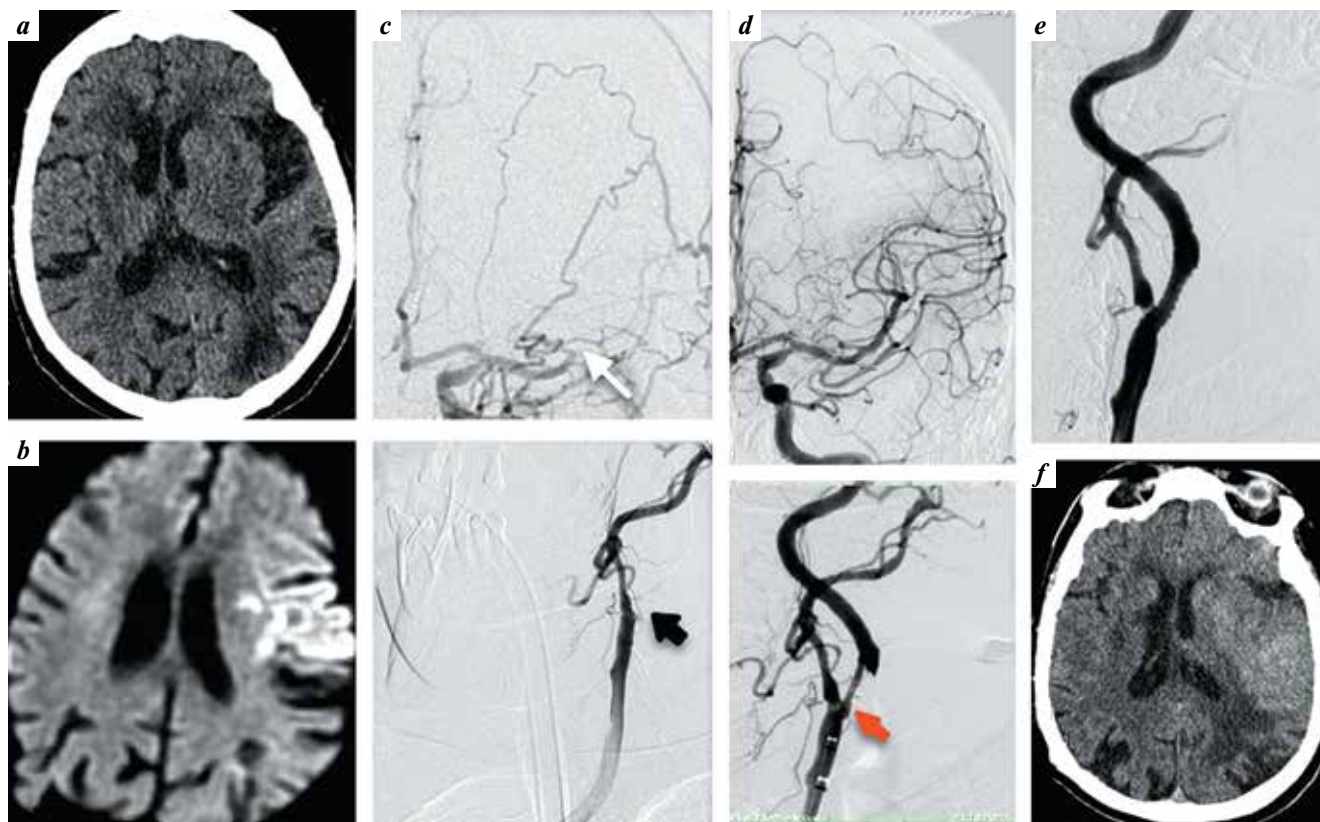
Data from computed tomography (CT), magnetic resonance imaging (MRI) and cerebral digital subtraction angiography of an 83-year-old patient hospitalized with an acute ischemic stroke symptoms in 320 minutes after the onset of the disease: a – CT scan at admission; b – MRI (DWI mode) at admission: hyperdense zone in the left temporal lobe; c – left carotid cerebral angiography at admission: occlusion of the extracranial internal carotid artery (ICA) (dark arrow), contrasting of the supraclinoid segment of the ICA due to extra-intracranial collaterals, and occlusion of the distal middle cerebral artery (MCA) (white arrow); d – left carotid cerebral angiography after ICA balloon angioplasty and MCA thrombectomy using a stent retriever. The blood flow through the intracranial arteries restored (mTICI – 3). Residual stenosis of the extracranial ICA up to 85 % (red arrow); e – cerebral angiography of the ICA after stenting; f – CT scan of the patient in 12 hours after surgery: without signs of hemorrhagic transformation
